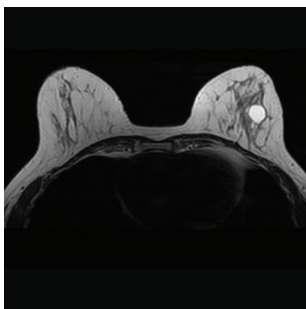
Same 51-year-old female patient. MRI of breast cyst.
